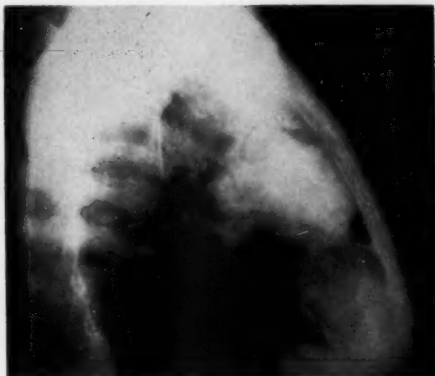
Lateral chest roentgenogram; suggested intrapulmonary location.
